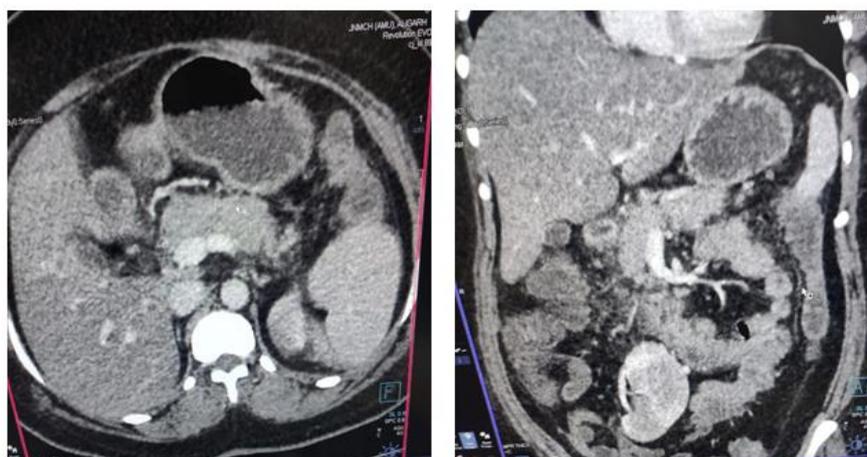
(A and B) CT of the abdomen demonstrates bulky body and tail of pancreas alongwith submucosal fat proliferation and fat stranding along medial wall of ascending colon
